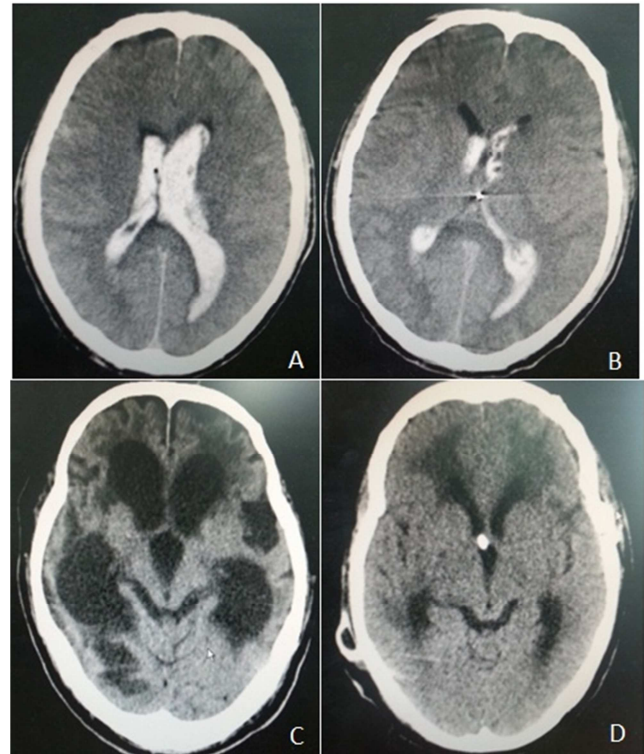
A patient was ventricle haemorrhage with associated hydrocephalus and blood in the third and both lateral ventricles. (A) Pre operative CT scan showing ventricle haemorrhage with associated hydrocephalus and blood in the third and both lateral ventricles; (B) an EVD was led in single lateral ventricle, and ventricle haemorrhage was smaller in CT scan two days later; (C) three month later, this patient shows headache, a declining level of consciousness and function. The clinical picture in CT is ventriculomegaly and periventricular edema; (D) After ventriculo-peritoneal shunt (VPS), it's brain CT scan showed that ventriculomegaly become to normal more or less and periventricular edema is alleviated.
